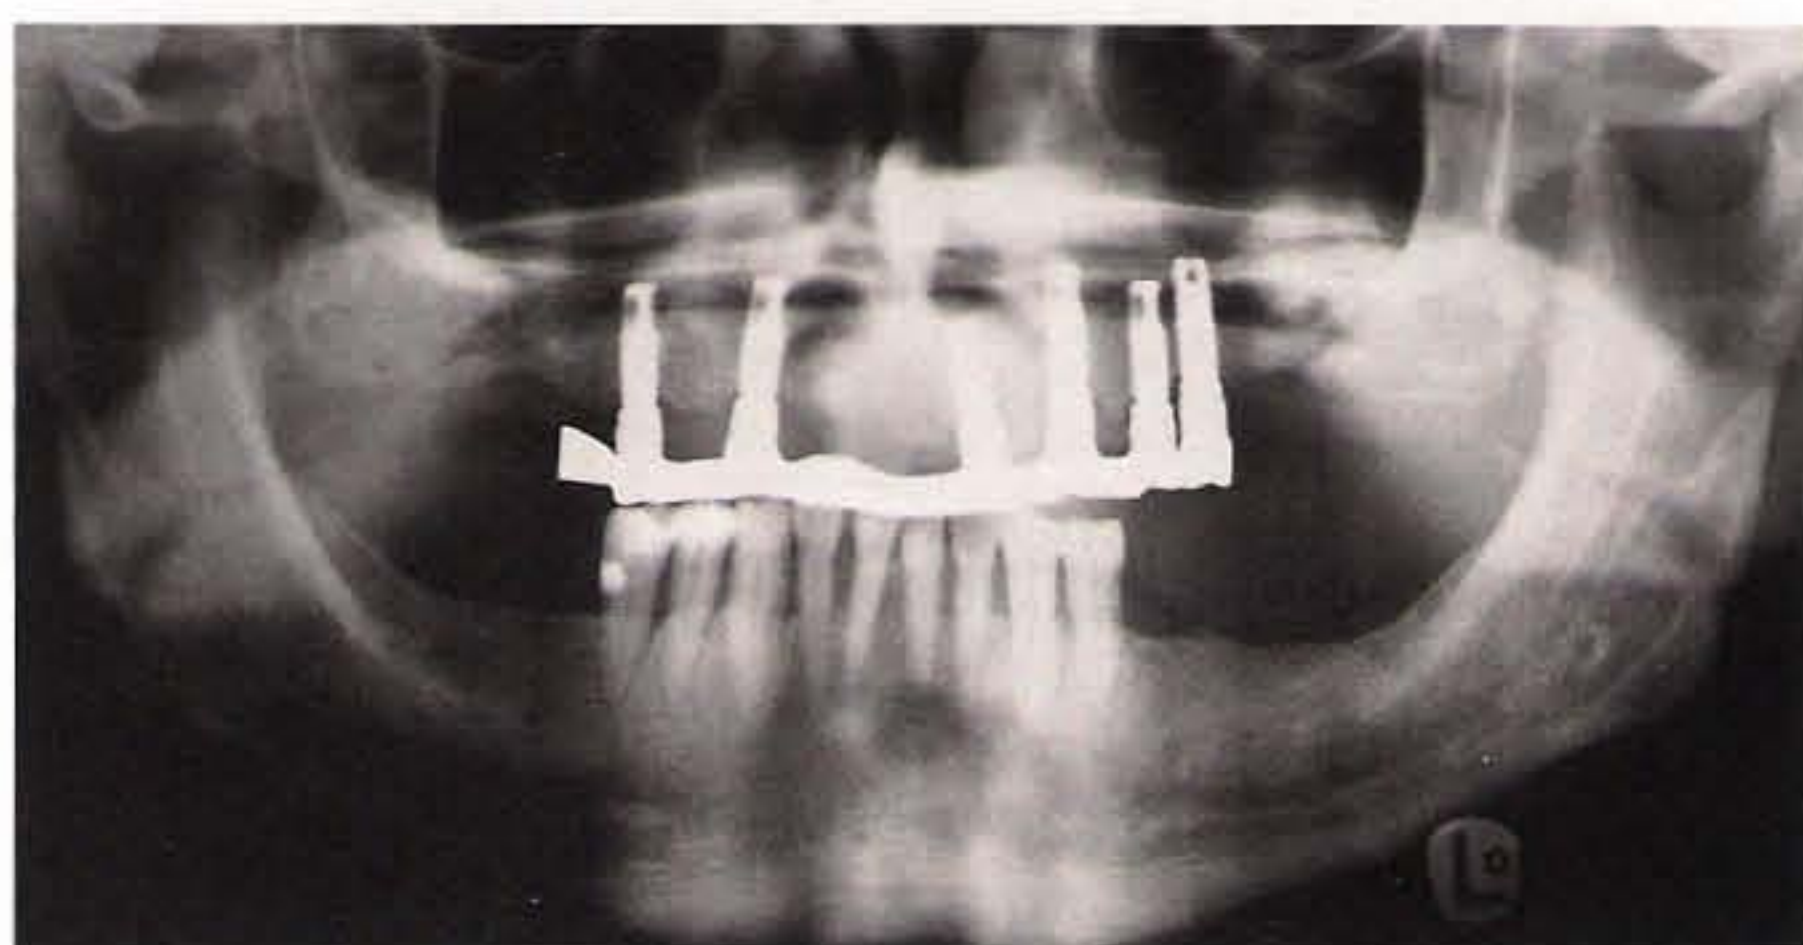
Control radiograph of the final prosthesis.
